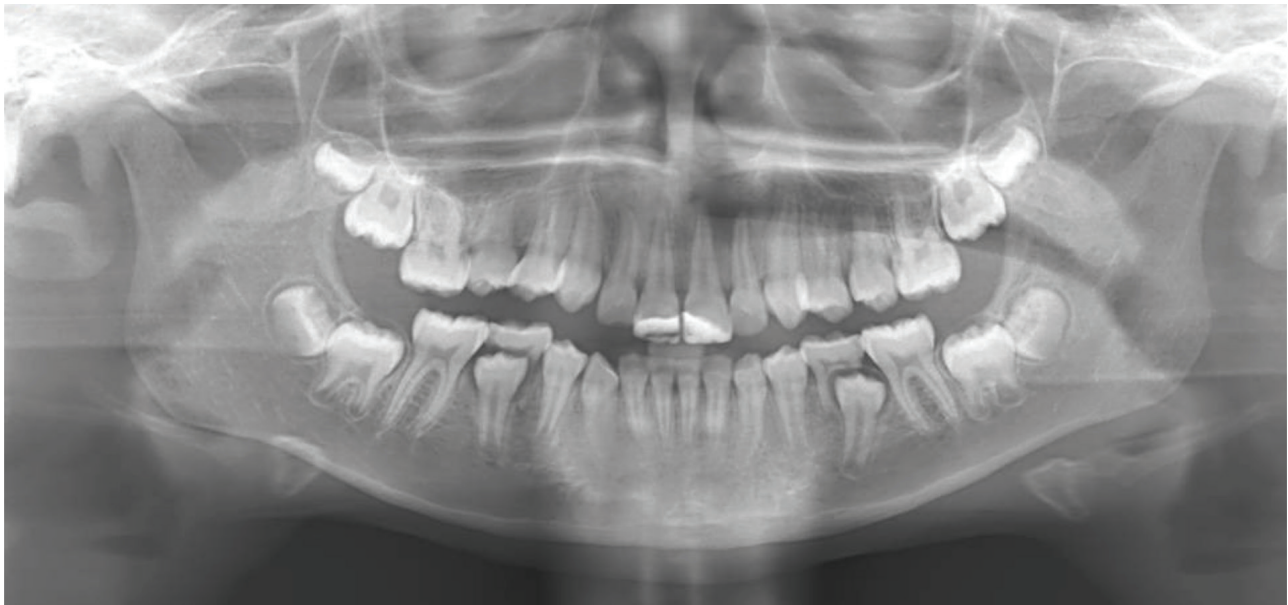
Panoramic radiograph
